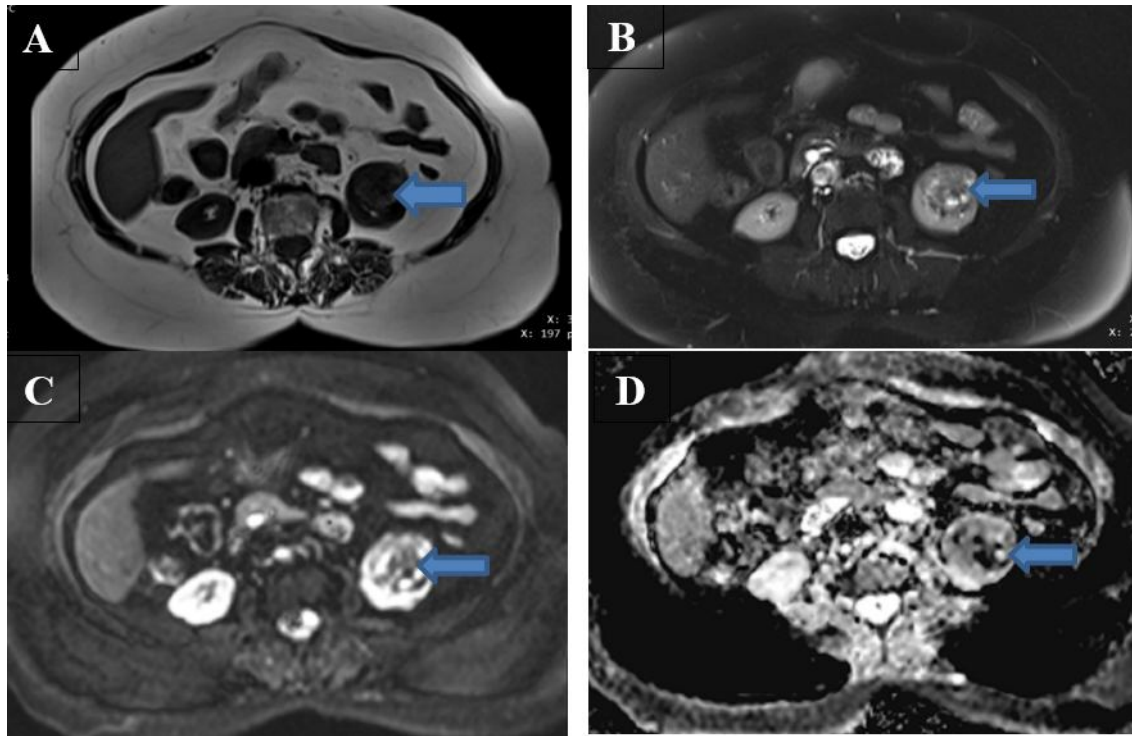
(A) Axial renal MRI (T1 sequence) shows left renal heterogeneously intense mass, (B) Axial renal MRI (T2 sequence) shows left renal hyperintense mass, (C) Axial renal MRI (DWI sequence) shows partially restricted diffusion, (D) Axial renal MRI (ADC) shows heterogeneous signal. Patient underwent nephrectomy and pathology revealed diagnosis as left papillary RCC
